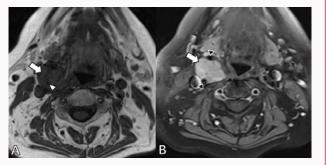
a) On T1-weighted image the lesion (arrow) is isointense compared to muscle. Note the small flow void (white arrowhead) within the mass. b) T1-weighted image with fat suppression after intravenous administration of gadolinium contrast. There is homogenous enhancement of the lesion.
